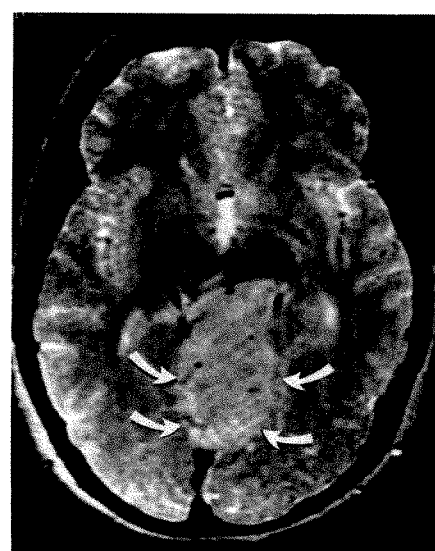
Case 10. Axial MR image (2000/80) shows large ganglioglioma arising in cerebellar vermis (arrows). Lesion is slightly hyperintense relative to normal brain parenchyma. On T1-weighted MR study (not shown), the lesion was also slightly hyperintense. Radiographically, the lesion is indistinguishable from Lhermitte-Duclos disease.
